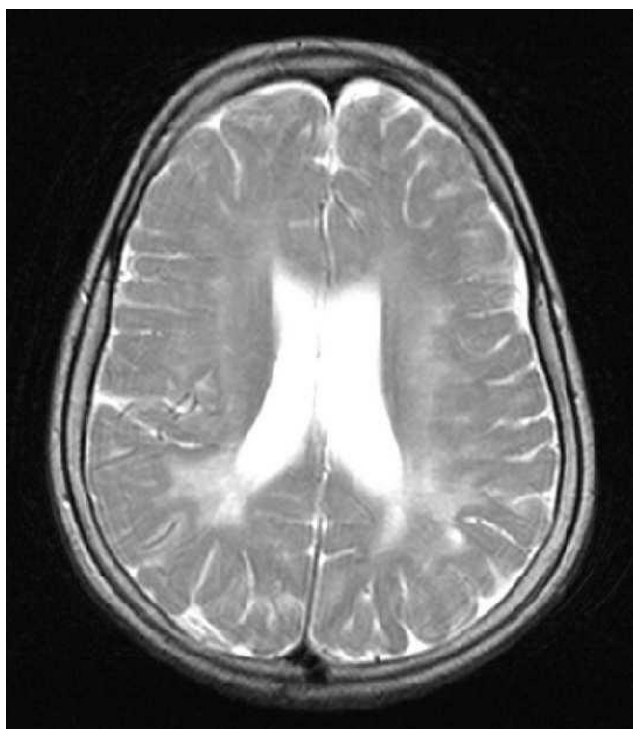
Brain magnetic resonance imaging of a 10-month-old infant (patient number 10) with neuronal ceroid lipofuscinosis-3 showing diffusely increased T₂-weighted signal in cerebral white matter bilaterally, which is more pronounced in the posterior portions.
